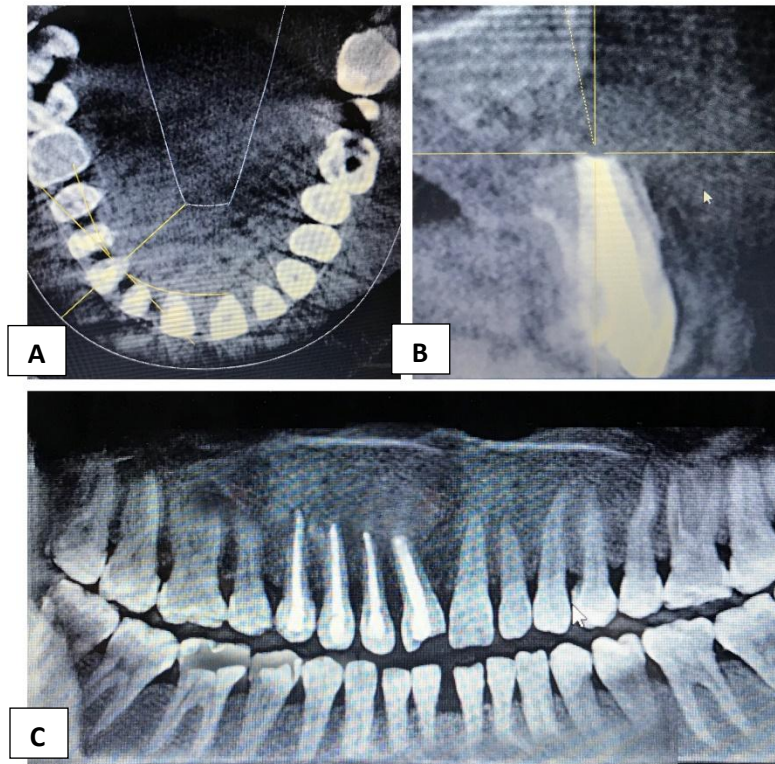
22 Months Post-Operative CBCT (A) Axial view(B) Cross Sectional view
